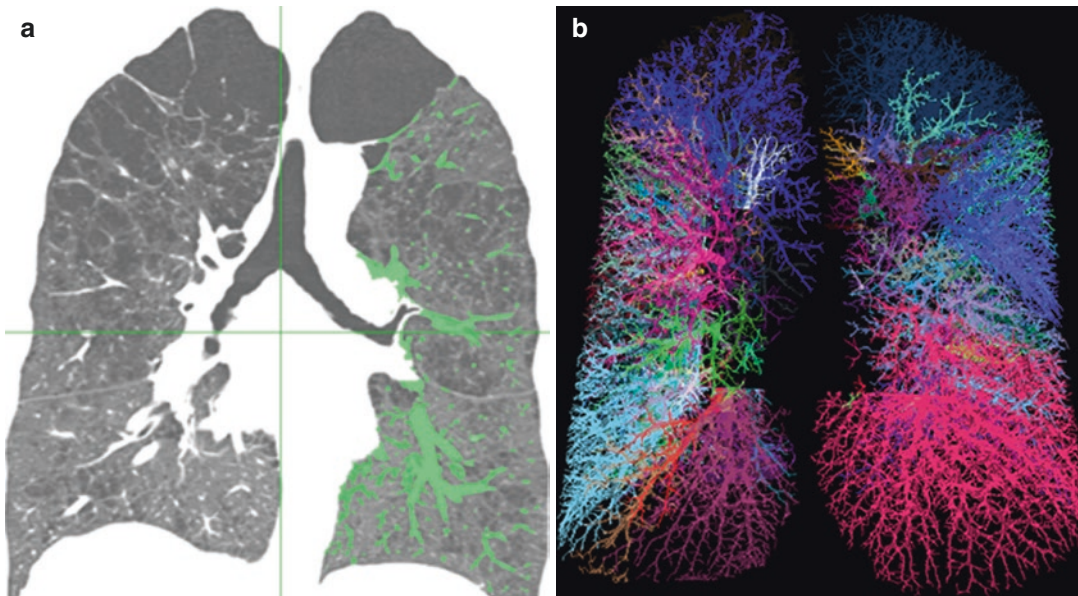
Vascular subbranches of lung. (a) Extraction vessels in CT and (b) Vascular tree reconstruction; random coloring; each color represents one vascular branch and mediastinal region is cropped
